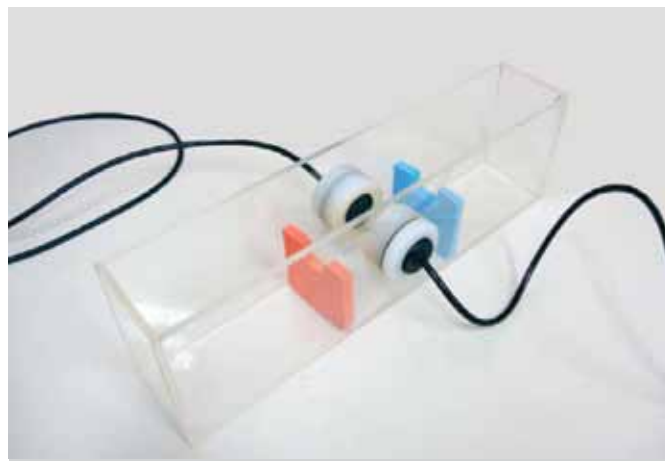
Measurement of ultrasound velocity via the transverse underwater technique.
